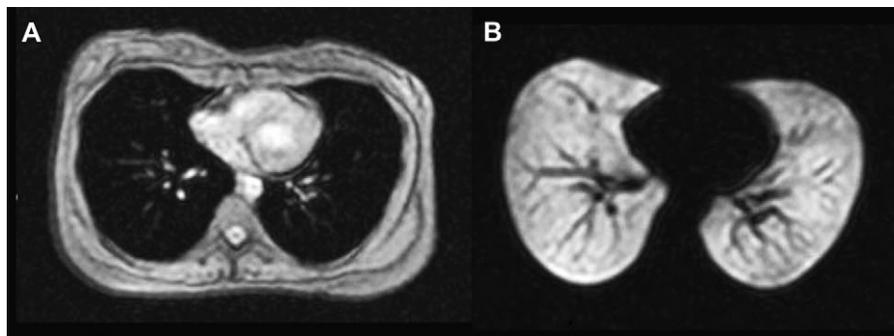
Healthy subject. A, Conventional axial hydrogen-based MR image of the chest showing the soft tissues of the chest. The airspaces of the lung are dark because of the low water content. B, A corresponding ³He MR image obtained immediately after inhalation of the hyperpolarized ³He gas shows a homogeneous bright appearance of the gas-filled airspaces. The dark linear structures within the lungs represent the pulmonary vessels. Reprinted with permission from de Lange et al.¹⁰
